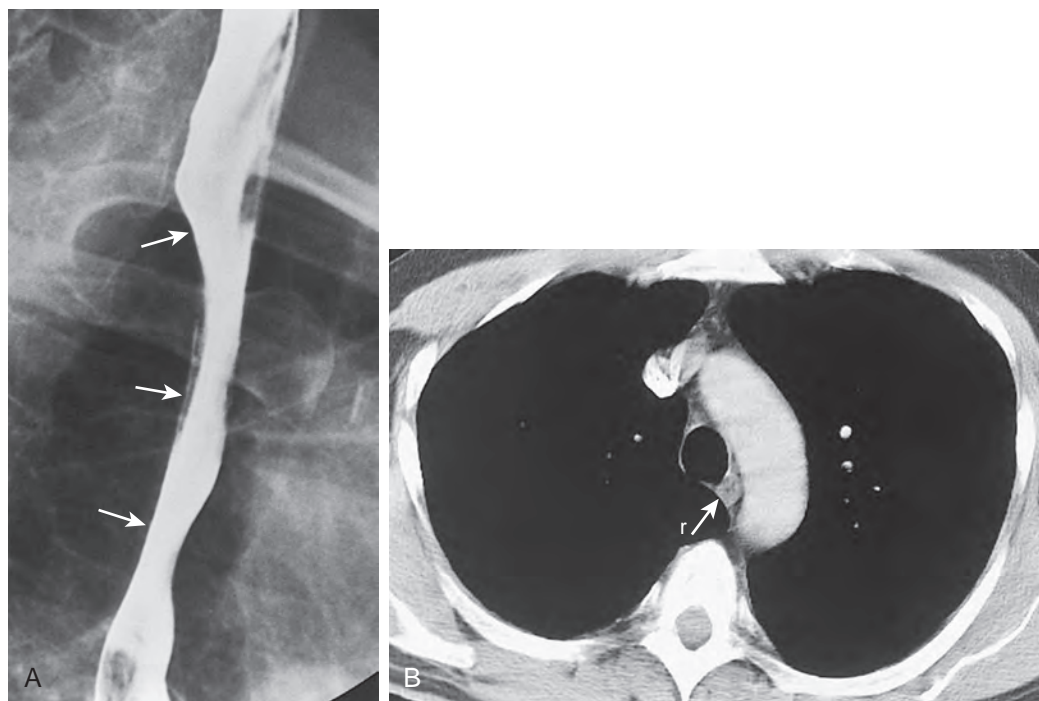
Extrinsic impression on the esophagus by a prominent right inferior supra-azygous recess. A. There is a smooth, gently sloping indentation (arrows) on the right posterolateral wall of the upper thoracic esophagus between the thoracic inlet and aortic arch. B. In the same patient, CT of the chest shows a prominent right inferior supra-azygous recess (r) impinging on the right posterolateral wall of the upper esophagus (arrow). (From Sam JW, Levine MS, Miller WT: The right inferior supra-azygous recess: A cause of upper esophageal pseudomass on double-contrast esophagography. *AJR* 171:1583–1586, 1998.)
